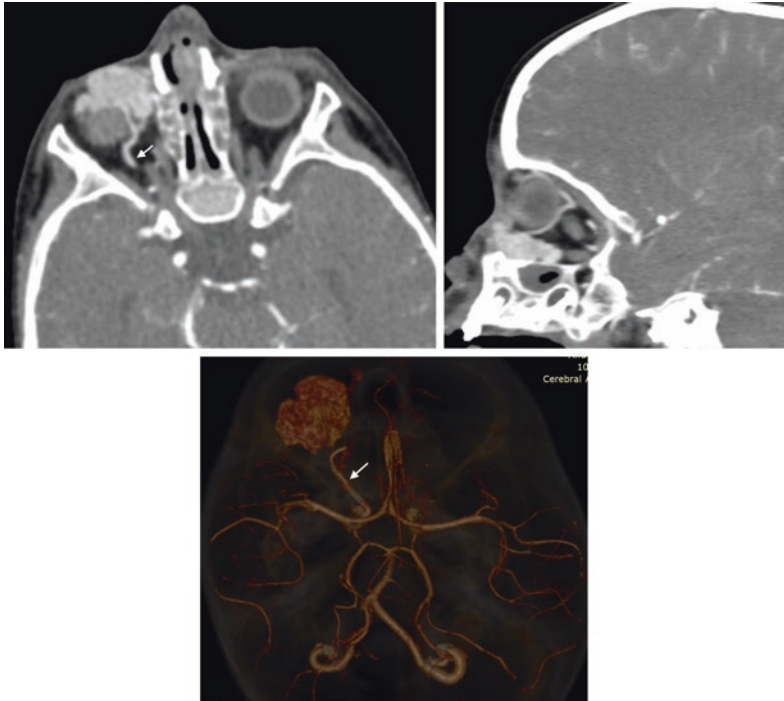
A 6 months old boy with right orbital capillary (infantile) hemangioma. a, b Post contrast CT images in axial and sagittal planes demonstrate extraconal avidly enhancing lesion, with prominent vessels seen at the periphery of the lesion representing feeders from the enlarged ophthalmic artery (arrow) c CTA reconstructed image showing dilated right ophthalmic artery (arrow)
